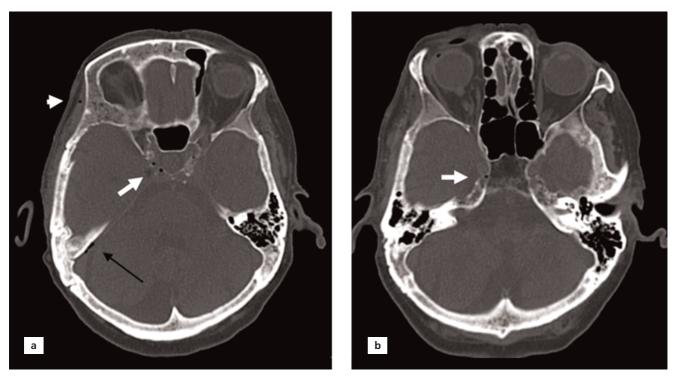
Bone window images of non-enhanced cranial CT. (a) Air bubbles in the cavernous sinus (white arrow), right sigmoid sinus (black arrow) and right superficial temporal vein (short white arrow); (b) air bubbles in the right inferior petrosal sinus (white arrow).
